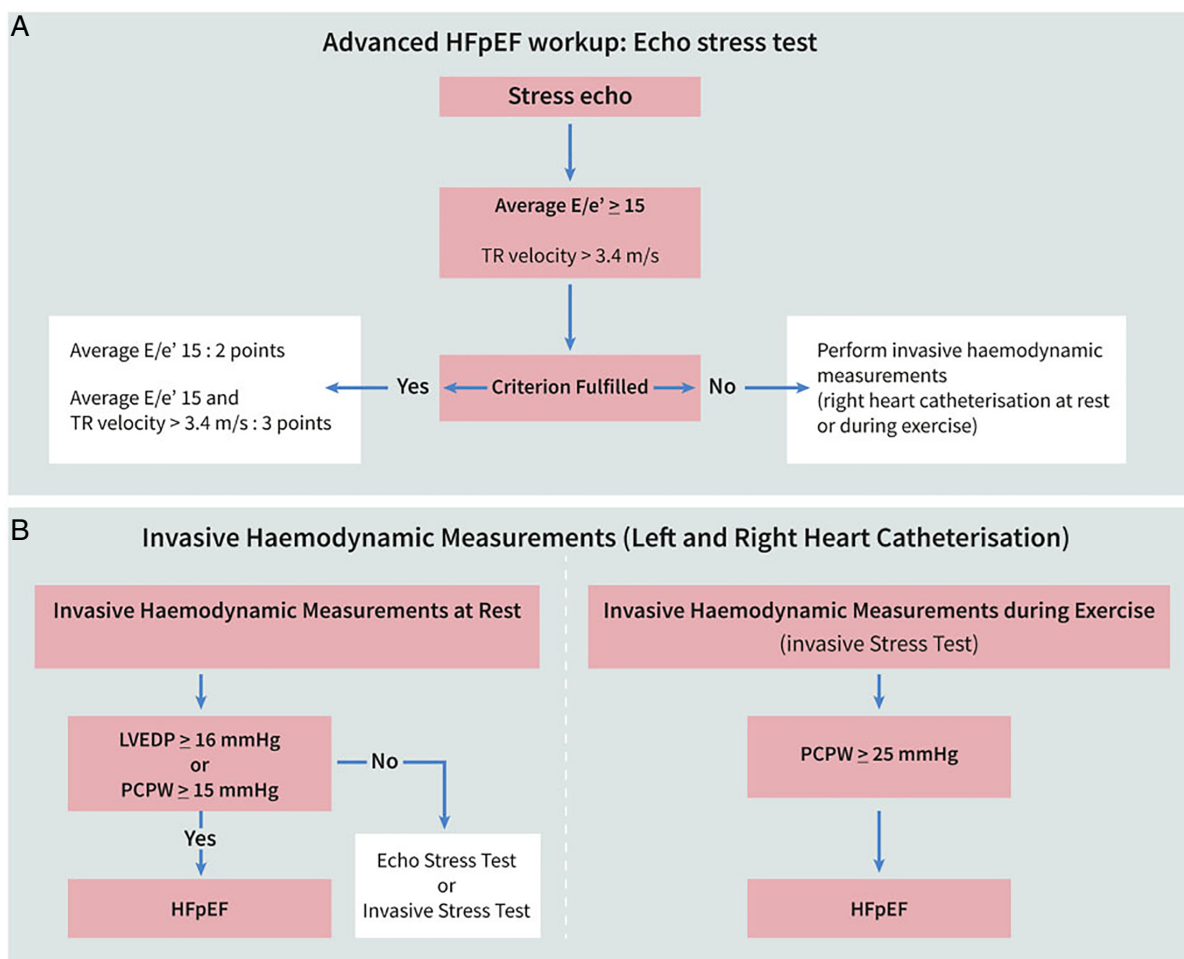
Step 3(F): Functional tests in cases of diagnostic uncertainty. (A) It shows the diastolic stress test workup with exercise echocardiography. If key haemodynamic abnormalities are identified, a definite heart failure with preserved ejection fraction (HFpEF) diagnosis can be made. (B) It shows the invasive haemodynamic measurements at rest (left) or during exercise (right) that may complement stress echocardiography and are recommended in cases with remaining diagnostic uncertainty. LVEDP, left ventricular end-diastolic pressure; PCWP, pulmonary capillary wedge pressure; TR, tricuspid regurgitation.
